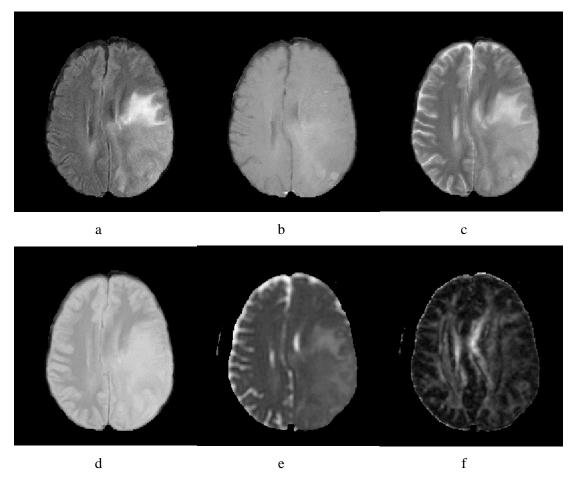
MRI images of low-grade glioma: a) FLAIR, b) T1-contrast, c) T2-weighted, d) PD, e) *p*-map, f) *q*-map.
